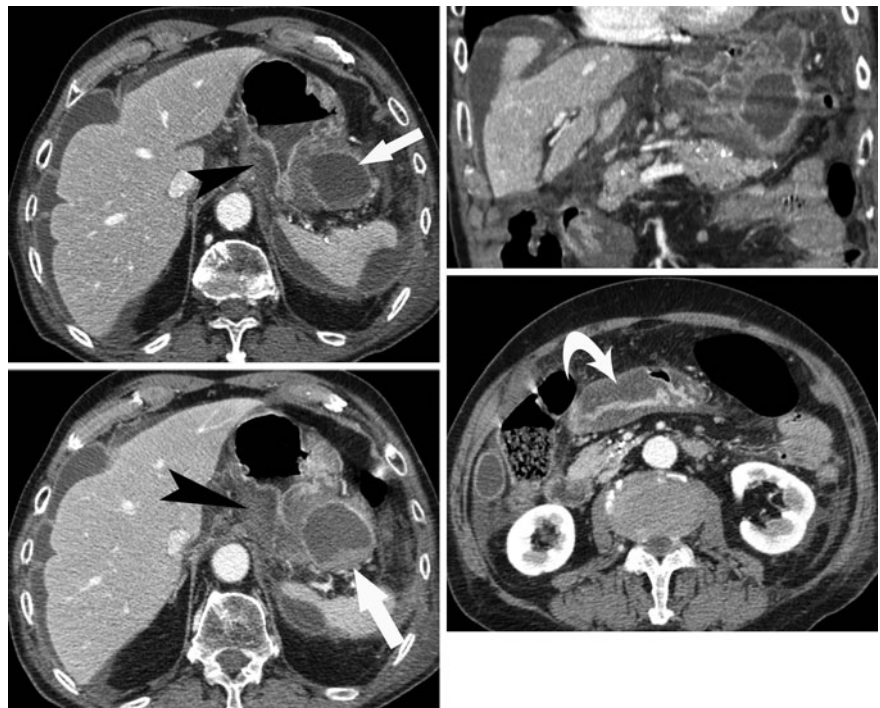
Acute caudal pancreatitis with pseudocyst and peritoneal fluid effusion. The CT scan confirms massive gastric parietal thickening affecting the lesser curvature (*point of black arrow*), the fundus and the antral region (*curved white arrow*). The pseudocyst (*white arrow*) is the site of bleeding responsible for the hyperdensity of the lower part. Gastric parietal thickening is massive, exceeding 20 mm
